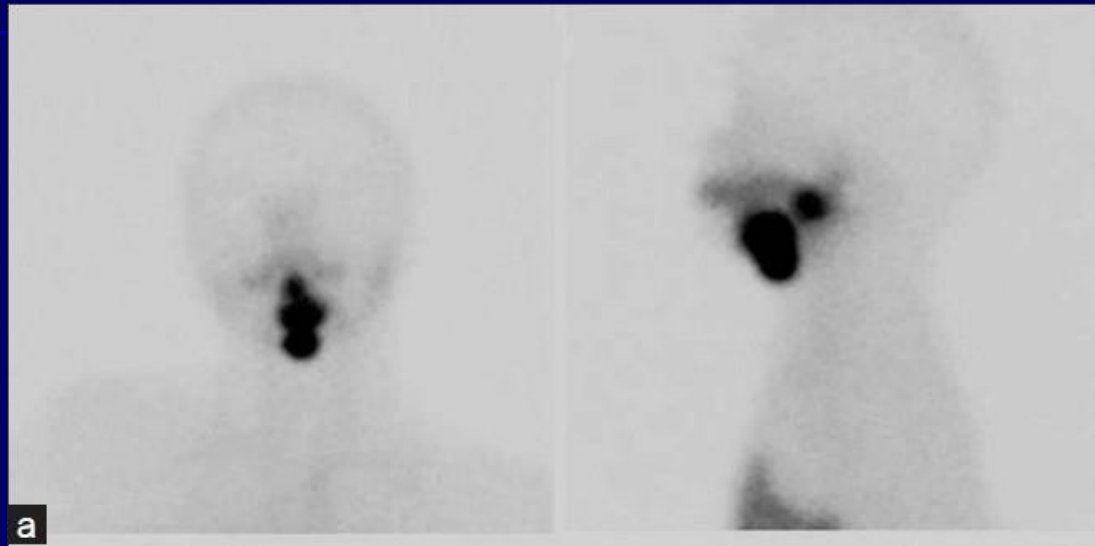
Images in a 2-week-old female patient with discordant scintigraphic and US findings and TSH of 35.05 μ IU/mL at initial scanning.
